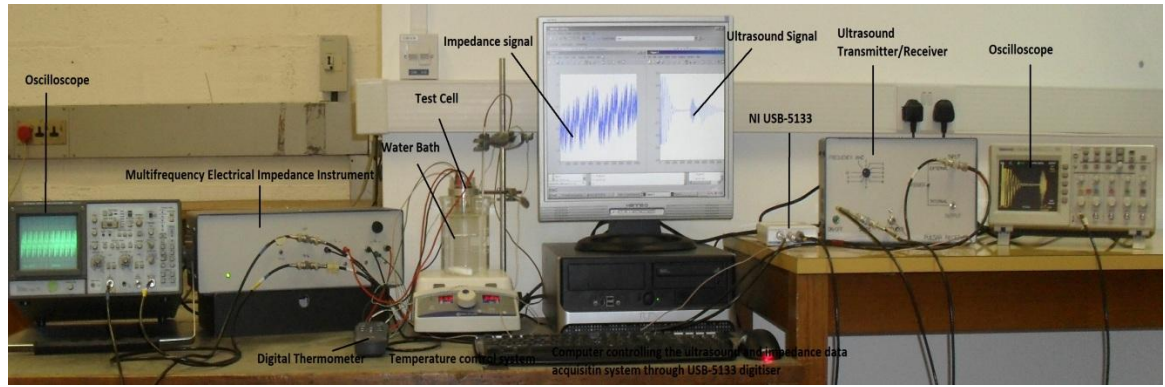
Showing the experimental setup for simultaneous ultrasound and electrical impedance measurement with the change of temperature. For data acquisition through the NI USB-5133 the interfacing to the computer and the EIT and Ultrasound transmitter/ receiver is done through functions written in C.
